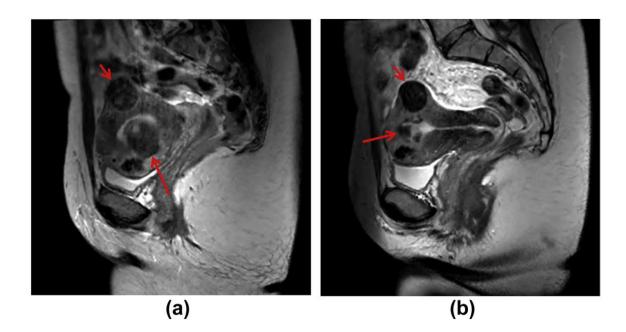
(a) Pre-embolization sagittal T2-weighted image showing submucosal (long arrow) and subserosal (short arrow) fibroids. (b) Six months after UAE, the submucosal fibroid (long arrow, 96% decrease in volume) had undergone a greater VR than the subserosal fibroid (short arrow, 50% decrease in volume) (Kalina et al, 2018).
